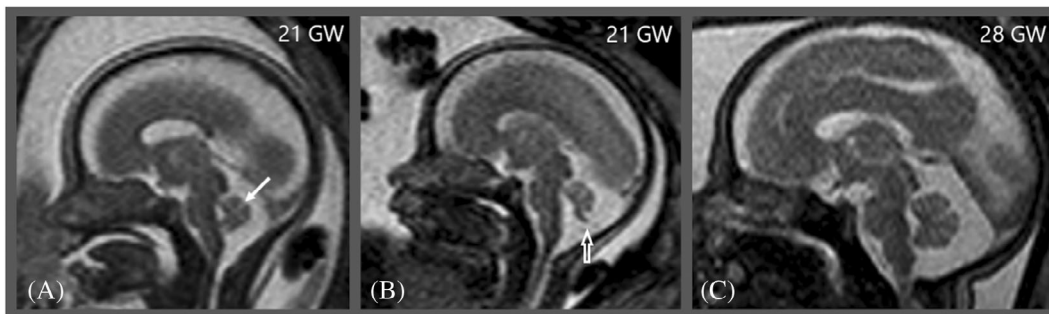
Second trimester appearances of the posterior fossa (A) sagittal T2-weighted image in a normal fetus at 21 GW shows that, as expected, the vermian has closed the fourth ventricle. Notice primary fissure (arrow); (B) sagittal T2-weighted image in another 21 GW fetus shows rotated vermian with normal size for the gestational age with wide communication between the fourth ventricle and the cisterna magna; notice the cerebellar tail sign (white arrow); (C) At 28 GW, sagittal T2-weighted image in the same fetus as B reveals completed rotation of the vermian and normal posterior fossa appearance
